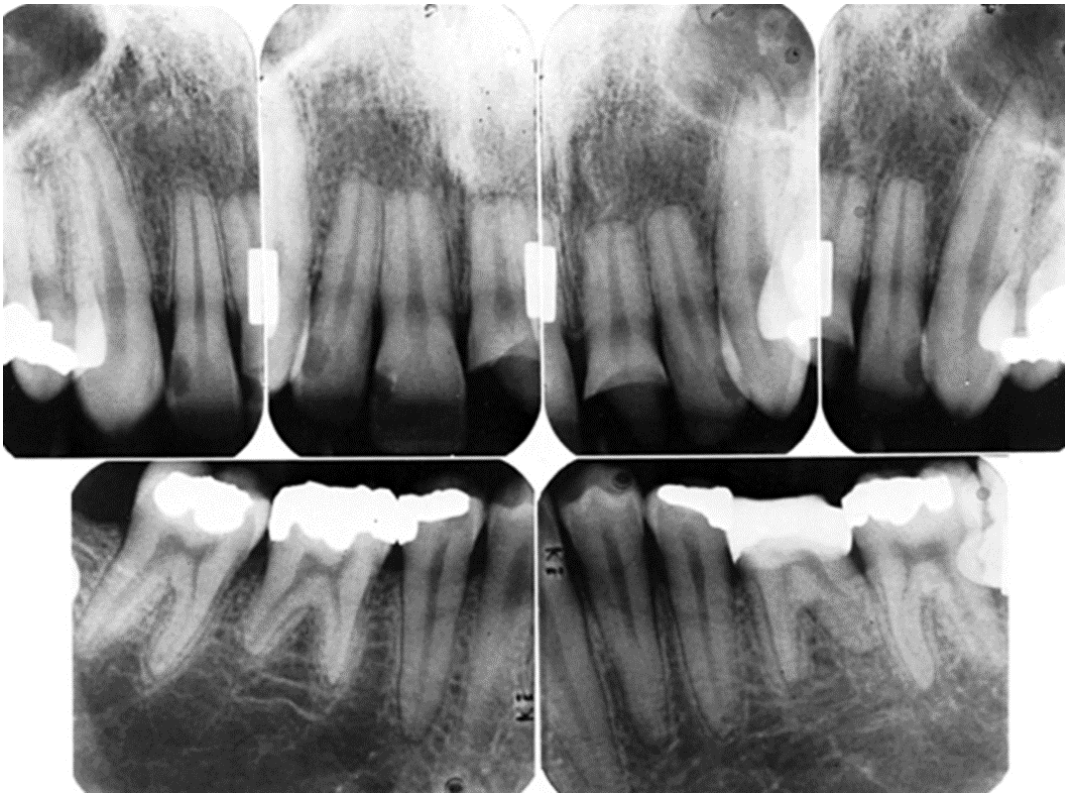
Radiographic image of erosion of the cervical areas of maxillary incisors.
